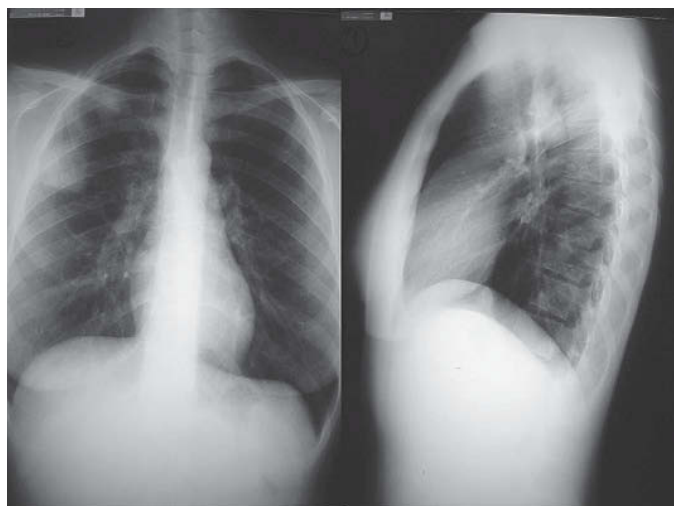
Plain chest radiograph.
